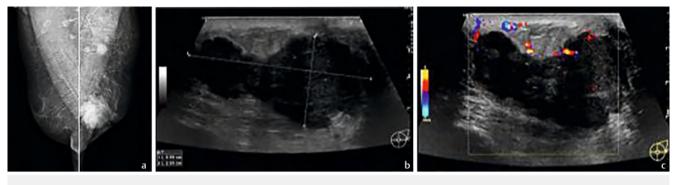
a Breast cancer on the left side, NST G2. Irregular, hyperdense focal finding on the left side on mammography, retromamillary, nipple retraction. b Complex cystic-solid lesion on ultrasound. c Increased vascularization in the lesion, on the periphery and peritumoral.
